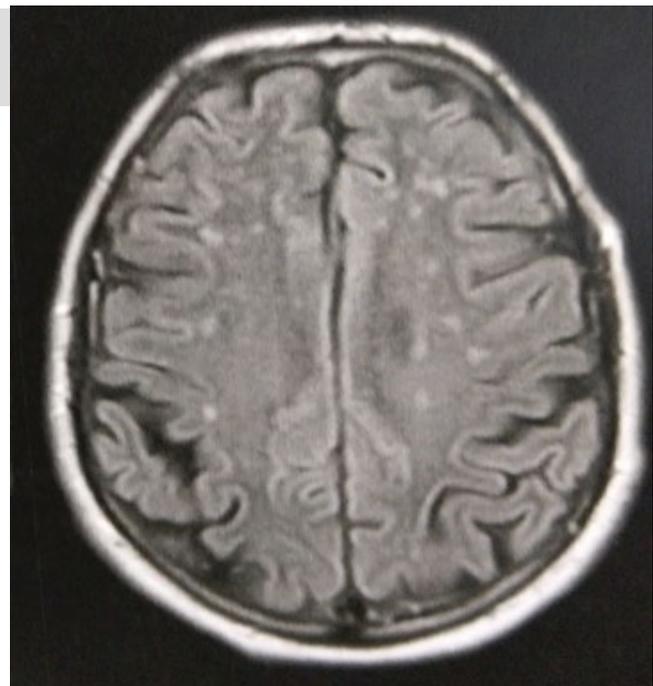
T2-weighted FLAIR MRI of brain showing punctiform hypersignals in the centrum semiovale and corona radiata.
